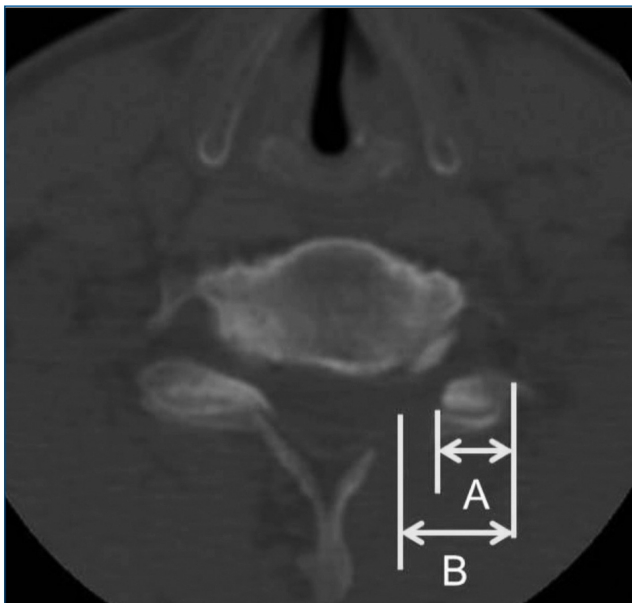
Postoperative computed tomography shows the remnant of facet joint (A/B).
